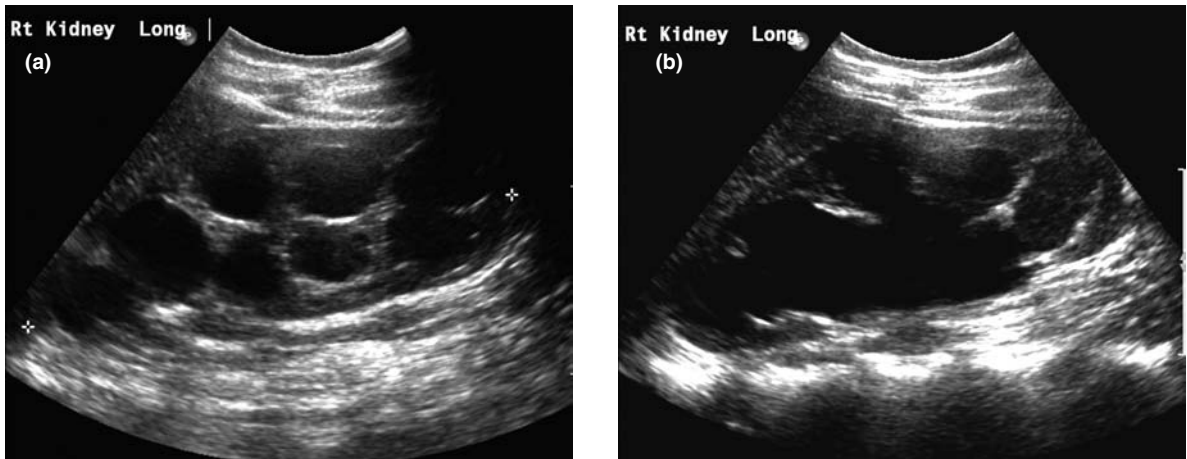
Ultrasound in a patient with (a) autosomal dominant polycystic kidney disease compared with a different patient with (b) marked hydronephrosis. Initial appearances are very similar but a skilled sonographer will be able to demonstrate that in the case of the hydronephrosis (b) the 'cysts' all interconnect since they are, in fact, calyces in a dilated collecting system.
